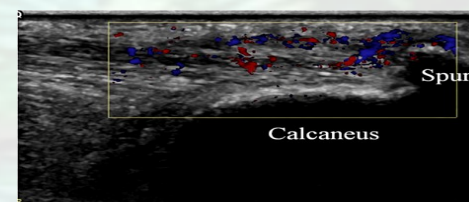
Mechanical Achilles tendon enthesopathy. Longitudinal section showing heterogeneous hypoechoic thickening of the posterior aspect of the enthesis with posterior spur and hyperaemia on colour Doppler examination.
